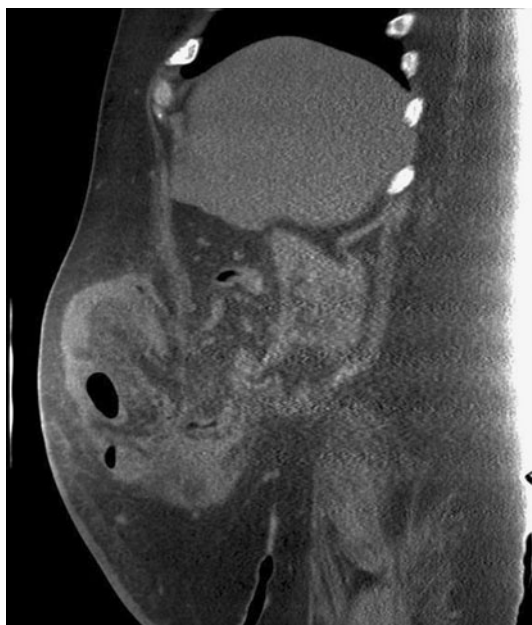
Abdominal computed tomography (CT) scan: giant parastomal hernia
